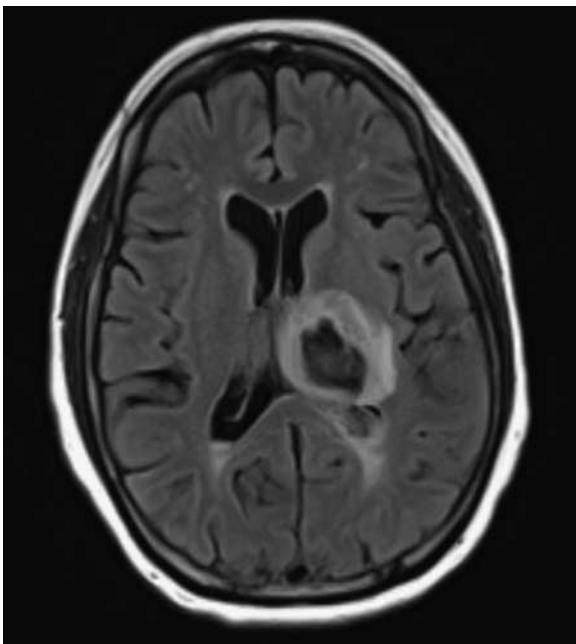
Initial MRI brain showing the left thalamic and intraventricular hemorrhage.
